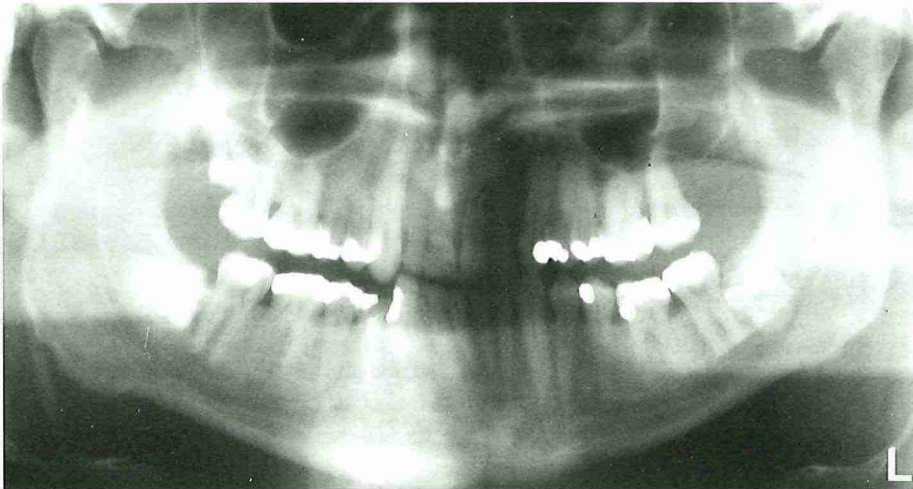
Orthopantomogram of patient presented in Fig. 3 showing normal eruption of the lower left first molar. The lower right third molar is now lying horizontally without contacting the second molar.
